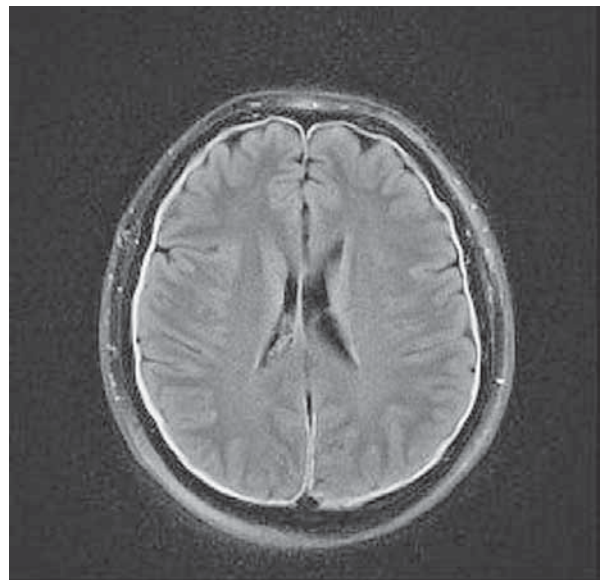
Axial FLAIR MRI shows mild diffuse bilateral thin layer of subdural effusion.
